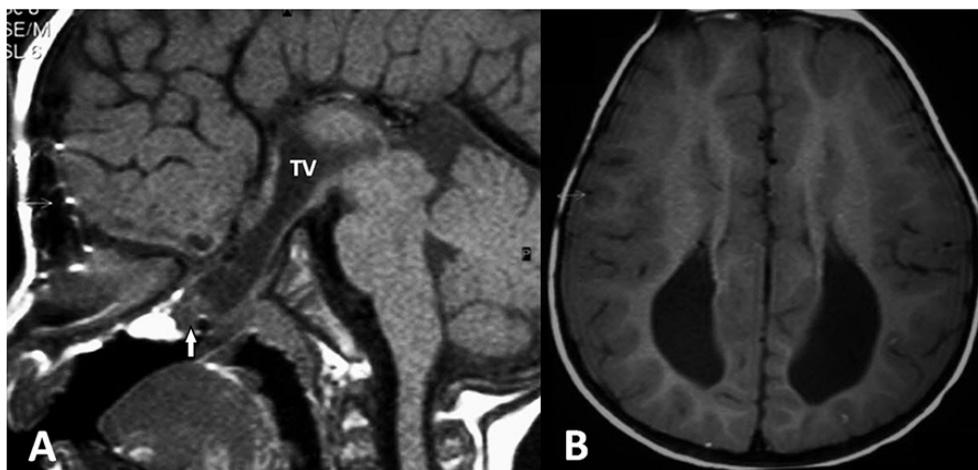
A) a coronal T1-weighted MR image demonstrate herniation of third ventricle (TV) through a defect in the pituitary fossa that produced a soft tissue mass within the posterior nasopharynx (arrow) and communicating with the third ventricle (TV); B) an axial T1-weighted MRI shows agenesis of the corpus callosum.
